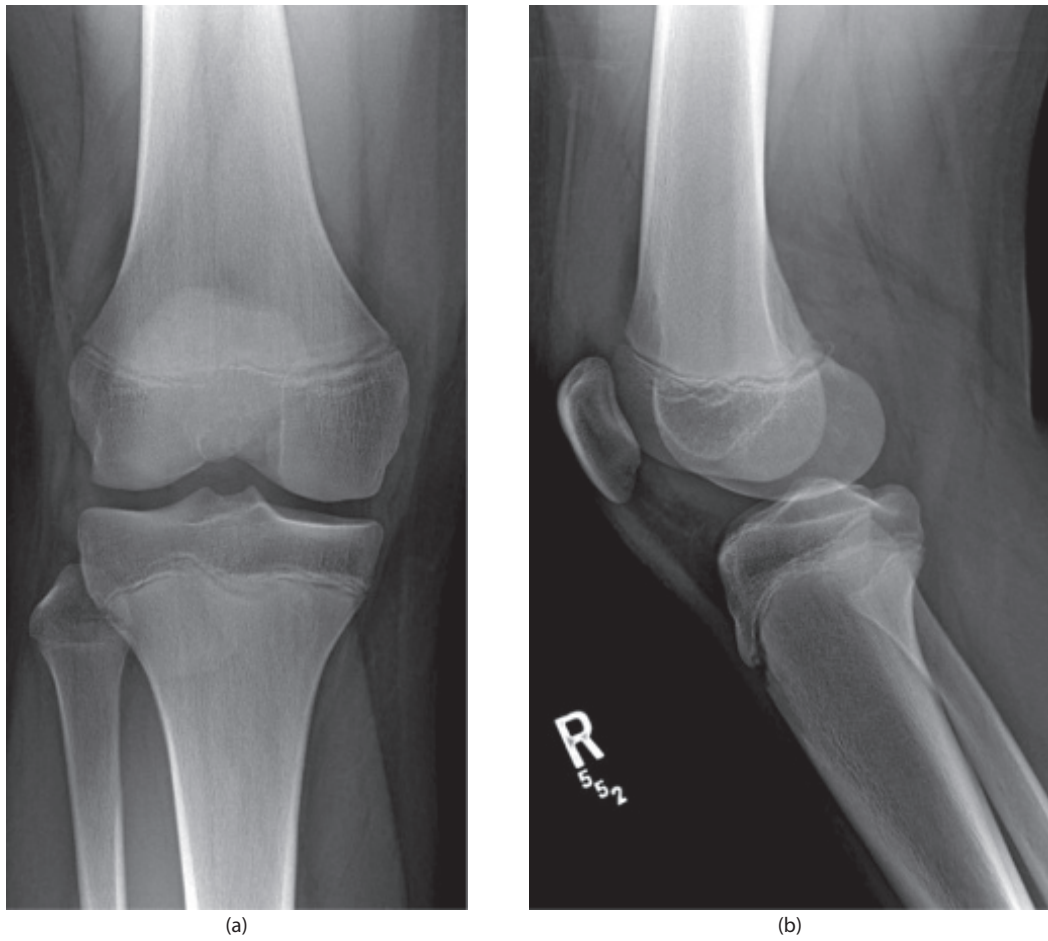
(a) and (b) Radiographs of a 14-year-old male who injured his knee while playing football show no obvious fracture. (c) and (d) A CT was obtained which showed a Salter-Harris III distal femur fracture. (e) The fracture was treated with percutaneous screw fixation.
